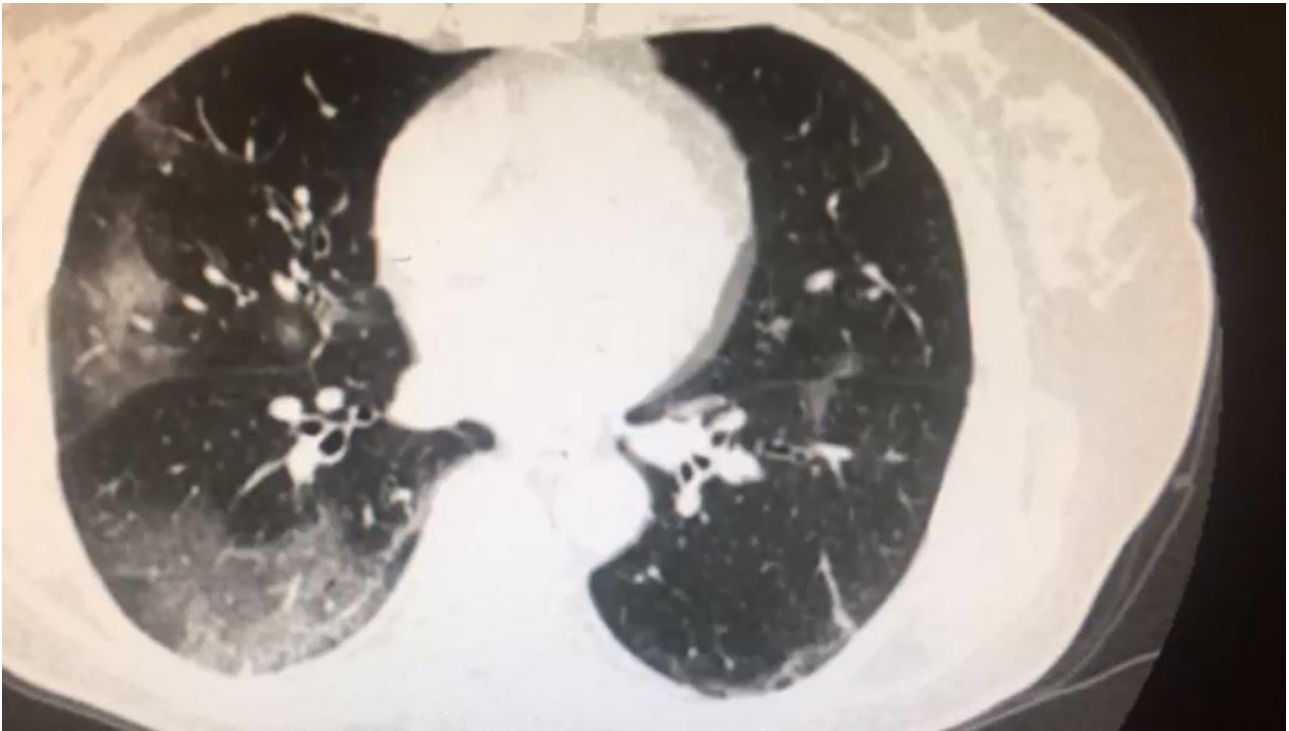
Chest computed tomographic images, obtained on 14.03.2020. Bilateral, peripheral ground-glass opacity
